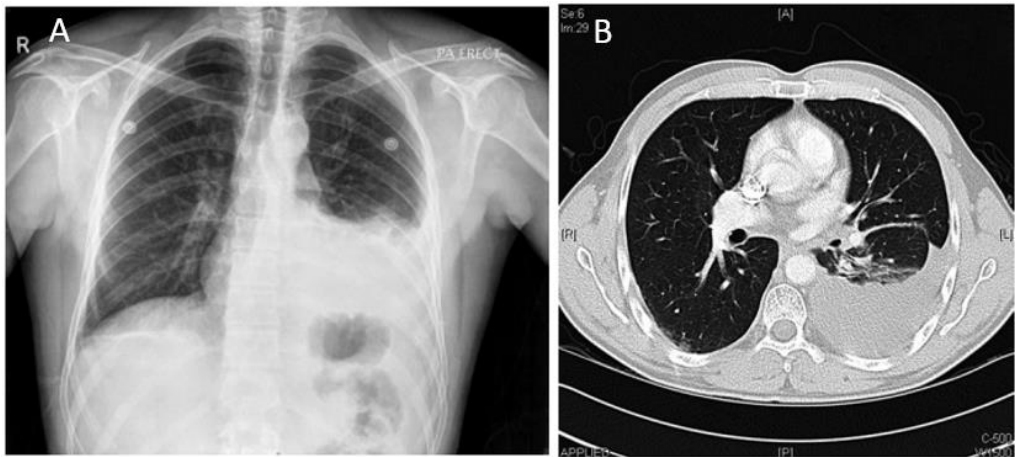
Imaging of MPM. (A) Chest X-ray of early MPM with unilateral pleural effusions. Progressive cases may exhibit pleural thickening and nodularity. (B) CT-scan of early MPM – simple pleural effusion (Naveed Z. Alam & Raja M. Flores 2020).
